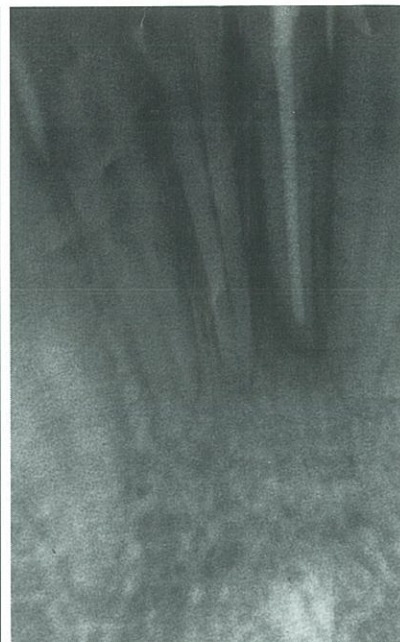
Case 1, preoperative radiograph. Note the complete radiolucency of the interproximal area between teeth nos. 24 and 25.
